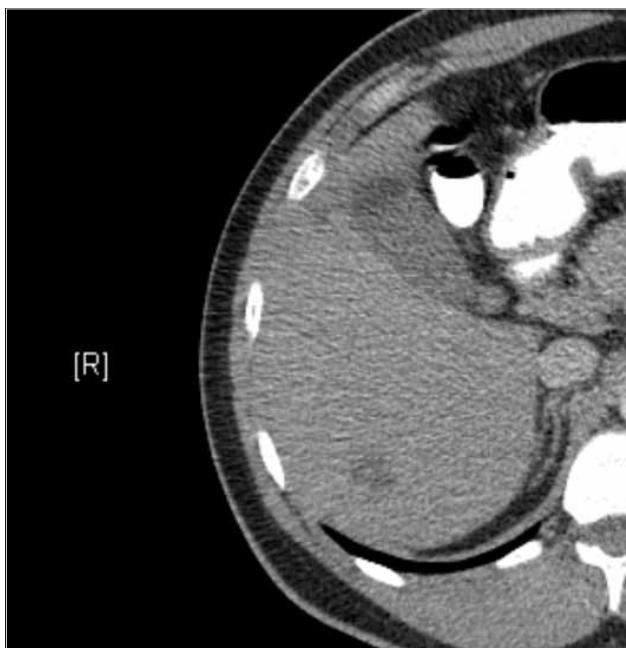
A single hypodense nodule is present in the posterior right lobe on axial contrast-enhanced CT in comparison with Figure 2
